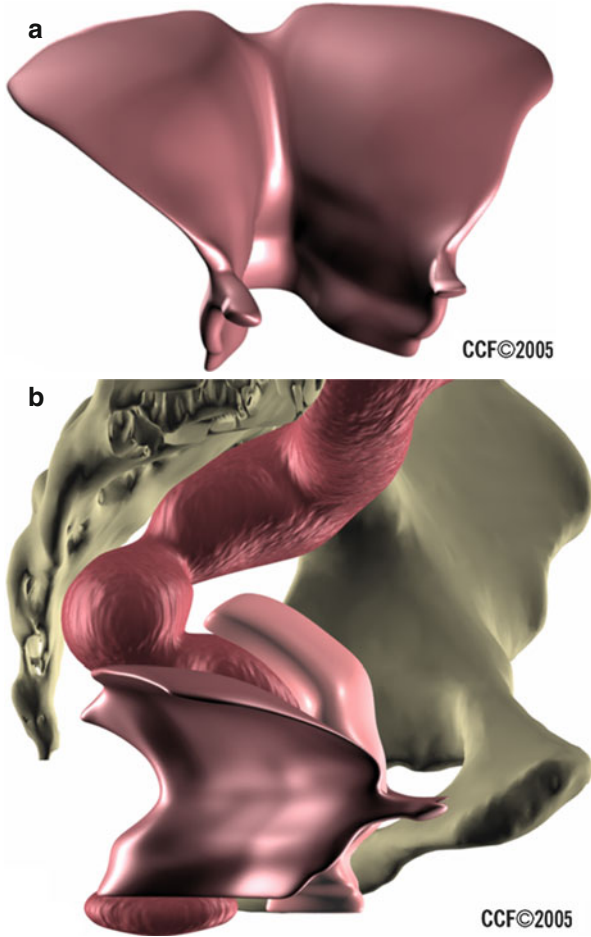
(a, b) Digitally enhanced MRI reconstruction of the levator ani at rest in a 23-year-old nulliparous woman. The levator ani gives a biconcave shape posteriorly and the puborectalis show as a sling imbedded in the muscle of the pelvic floor (Reprinted with permission from Cleveland Clinic Center for Medical Art and Photography© 2004–2009 and Matthew Barber, MD)
